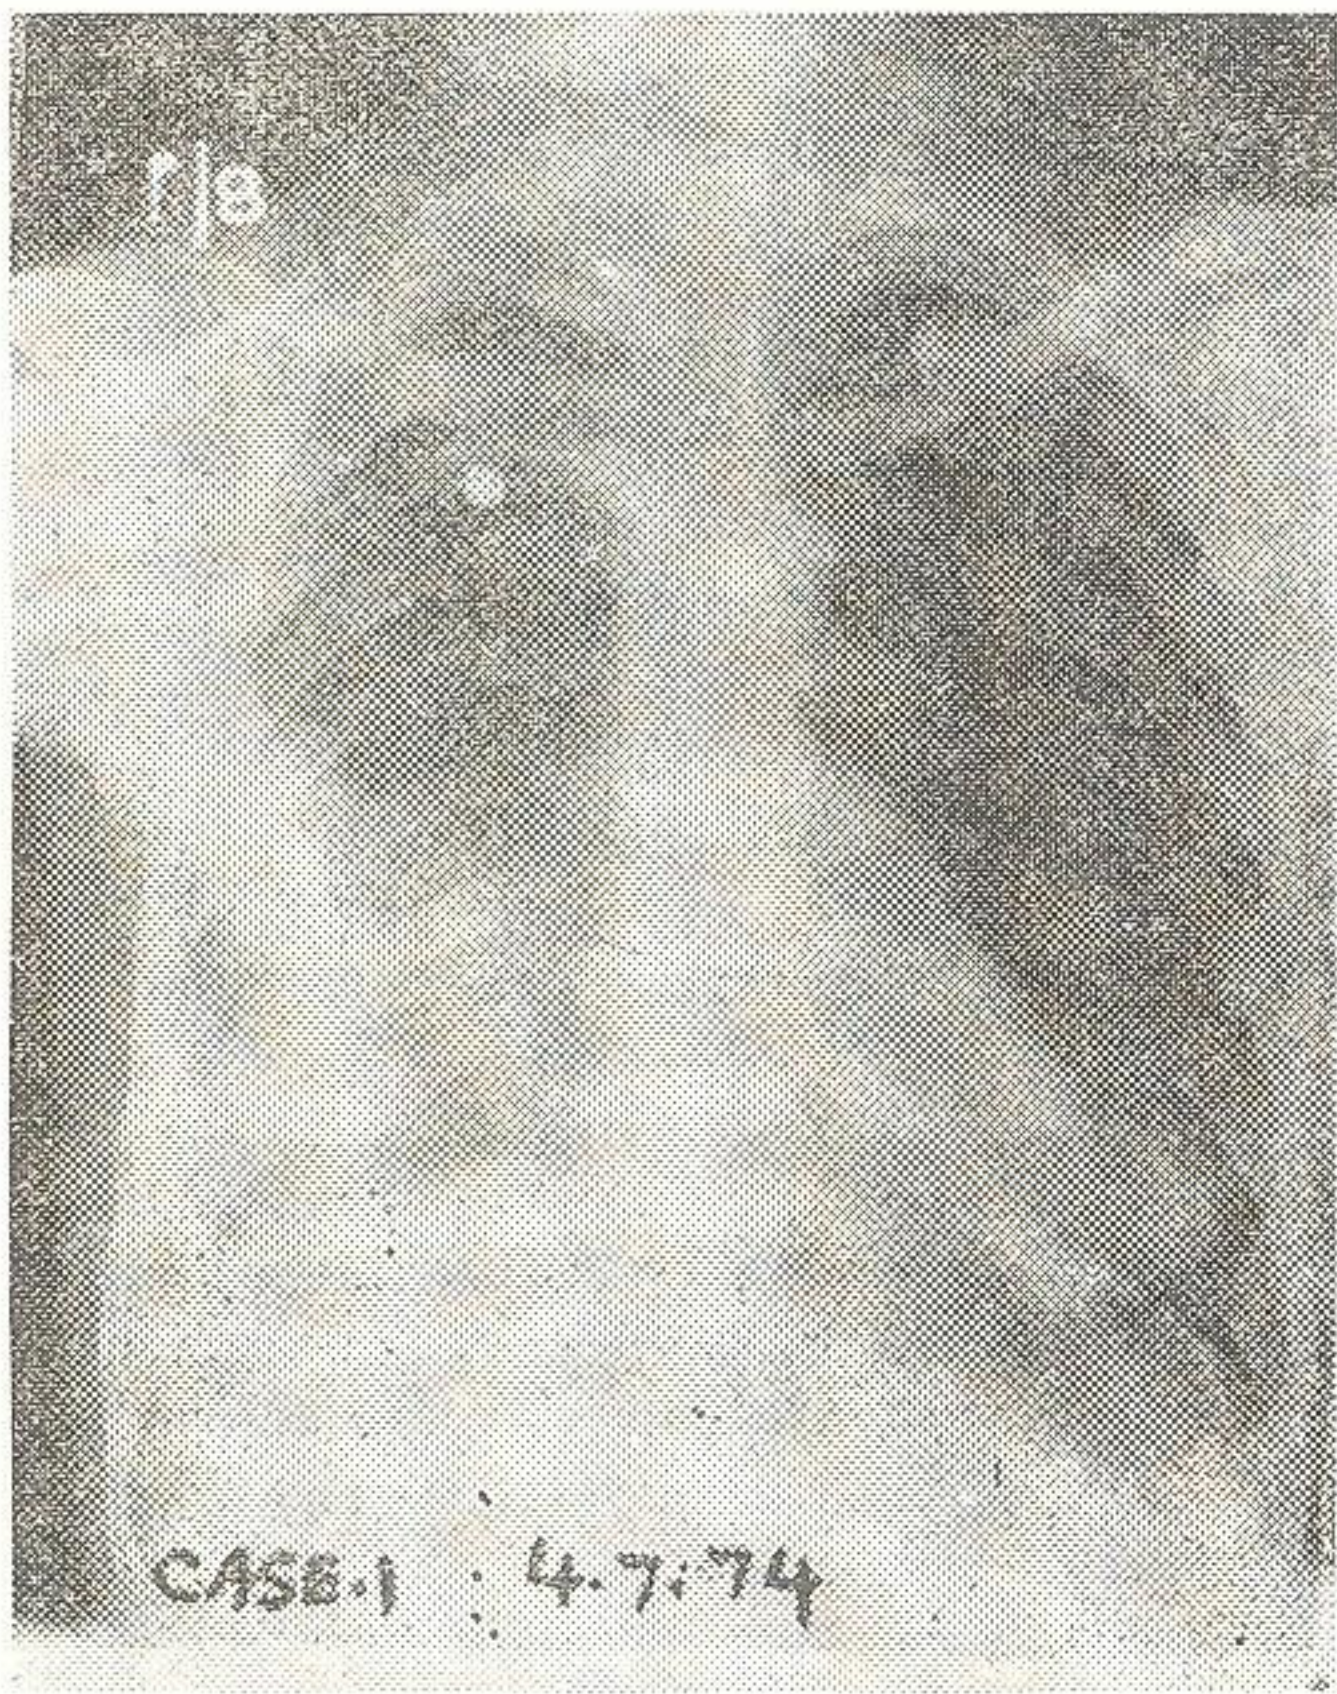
Case 1 (4-7-1974). X-Ray chest after antiamebic treatment and a dry tap with clearance of the empyema and residual pleural reaction.
